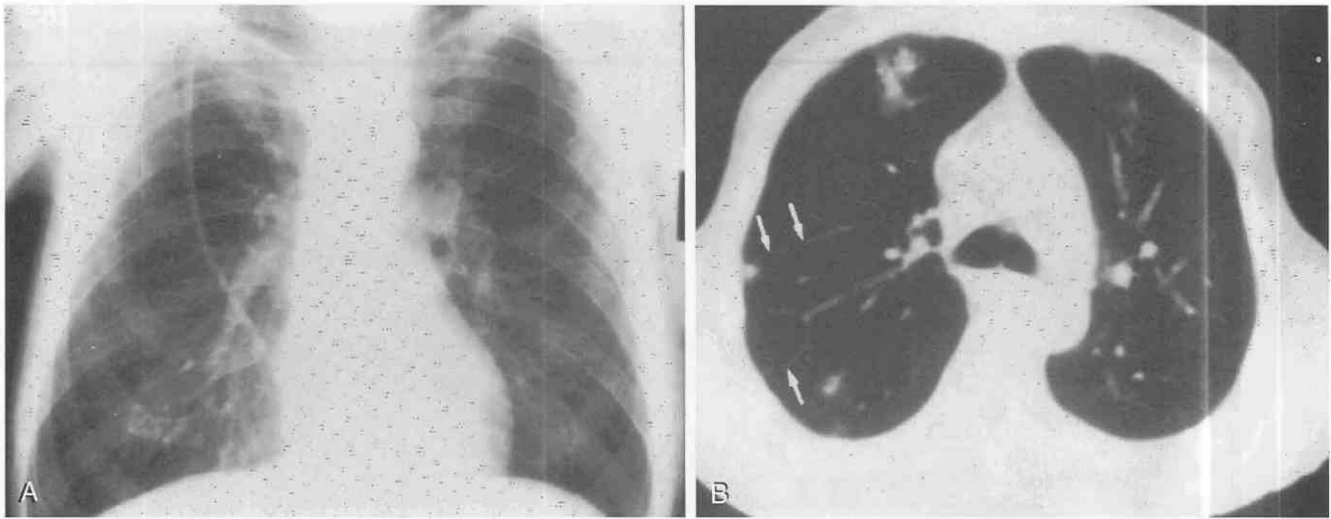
Unexplained fever in a patient with acquired immunodeficiency syndrome (AIDS). A, Chest film shows central venous line but no obvious infiltrates. B, CT identifies multiple inflammatory nodules with feeding vessels (arrows), compatible with a diagnosis of septic emboli. The source of the septic emboli was found to be the central venous catheter that had become infected. (B, From Kuhlman JE, Fishman EK, Burch PA, et al: Diseases of the chest in AIDS: CT diagnosis. *Radiographics* 9:827-857, 1989.)
